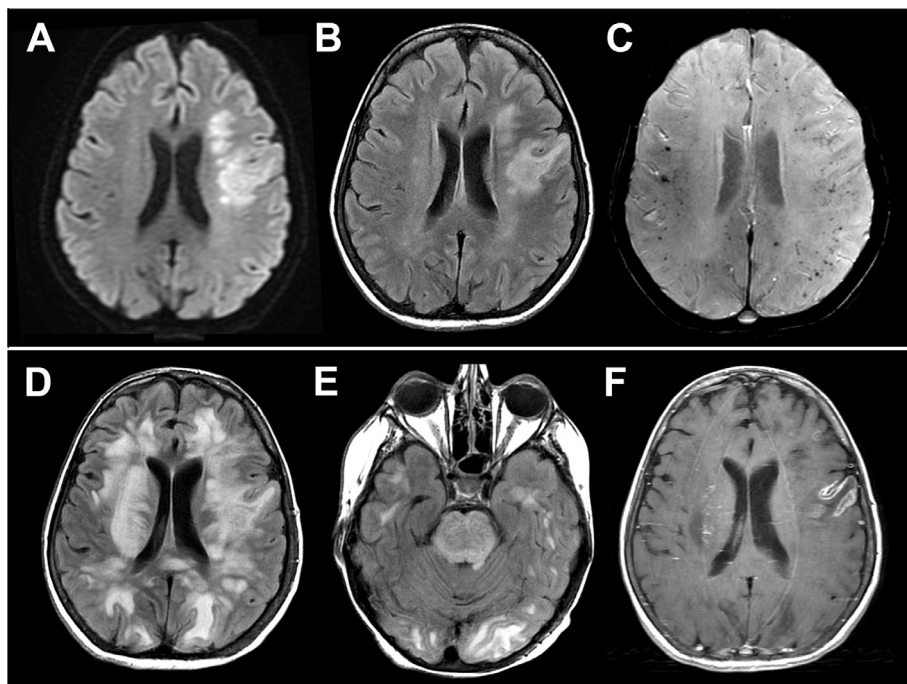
Axial diffusion weighted (A) and fluid attenuated inversion recovery (FLAIR) (B) MRI 11 days after presentation showing acute/subacute left frontal infarction. Axial susceptibility weighted imaging (C) showed innumerable hypointense foci, likely microhaemorrhages, throughout both cerebral hemispheres. Progress axial FLAIR MRI performed 6 days later showing extensive confluent altered signal intensity in the white matter of both cerebral hemispheres (D), the cerebellum (not shown) and the brainstem (E). Gadolinium-enhanced axial T1-weighted MRI showing scant or minimal enhancement in the white matter, and (F) gyriform enhancement of the subacute left frontal infarction.
